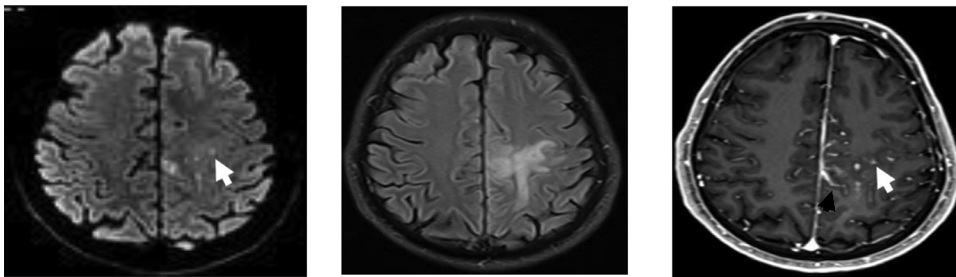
Axial DWI (A), FLAIR (B), and contrast-enhanced T1-weighted image (C). Perivascular enhancing lesion with restricted diffusion (white arrow) with vasogenic edema (B) and leptomeningeal enhancement (black arrow) in the frontoparietal white matter.
